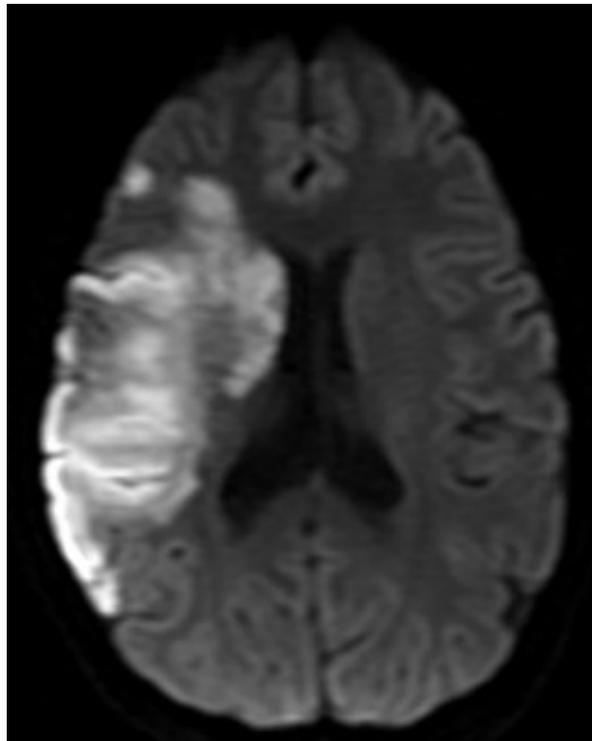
DWI: ischaemic infarct in the right middle cerebral artery identified using DWI imaging [<http://www.neurology.org/content/74/24/1946/F2.expansion.html>, accessed on 15/04/2013]
